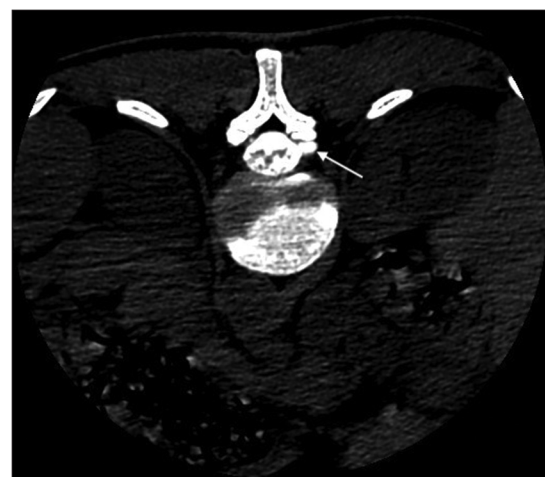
Subdural fluid collections in CT-T2 scanning, patient before EBP under CT guidance.
